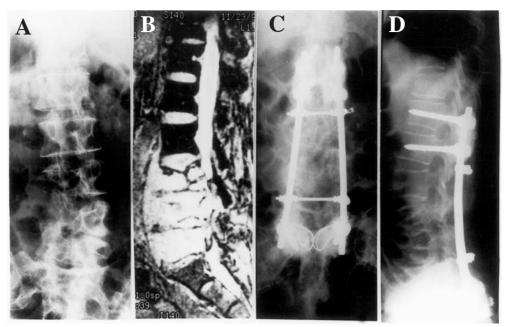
70 years old male presented with colon cancer. (A-B) Pre-operative anteroposterior radiograph and sagittal magnetic resonance scan of lumbar spine showing destruction of L3,4,5 body with retropulsion of body detritus into the spinal canal; (C-D) Postoperative radiographs showing stabilization with pedicle screws and bone cement in the posterior.
